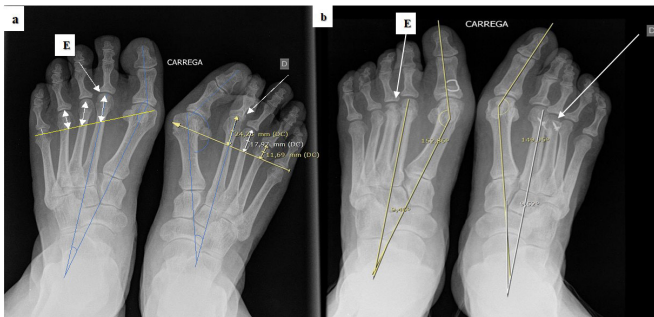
(a) Preoperative AP weight bearing radiograph of the bilateral feet with symptoms of metatarsalgia showing disturbed Maestro's harmonious curve with subluxation of 2nd metatarsophalangeal joint on the right foot (D) in comparison to left foot (E). Symptomatic hallux valgus deformity of right (D) great toe. Radiological assessment of hallux valgus observed with hallux valgus angle and inter-metatarsal angle increased on right side (D), compared to the left side (E). (b) AP weight bearing radiograph of bilateral feet of one year follow up with no symptoms of metatarsalgia showing maintained Maestro's harmonious curve bilaterally. The Maceira's triple osteotomy not fixed on left (E) side and fixed on right side (D). Left side (E) hallux valgus corrected with distal Chevron osteotomy combined with Akin osteotomy showing improved hallux valgus angle of 31 degree (at 1 year) and intermetatarsal angle of 9 degrees. The right (D) side, hallux valgus correction not done with hallux valgus angle remained at 27 degrees (1-degree progress) after 1 year with intermetatarsal angle of 9 degrees.
